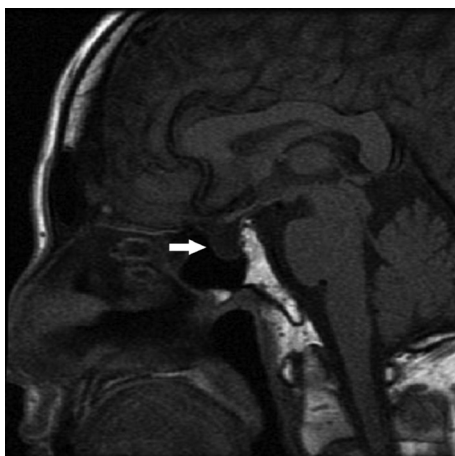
Sagittal image obtained by MRI showing the hypoplastic pituitary gland of the patient (arrow).
